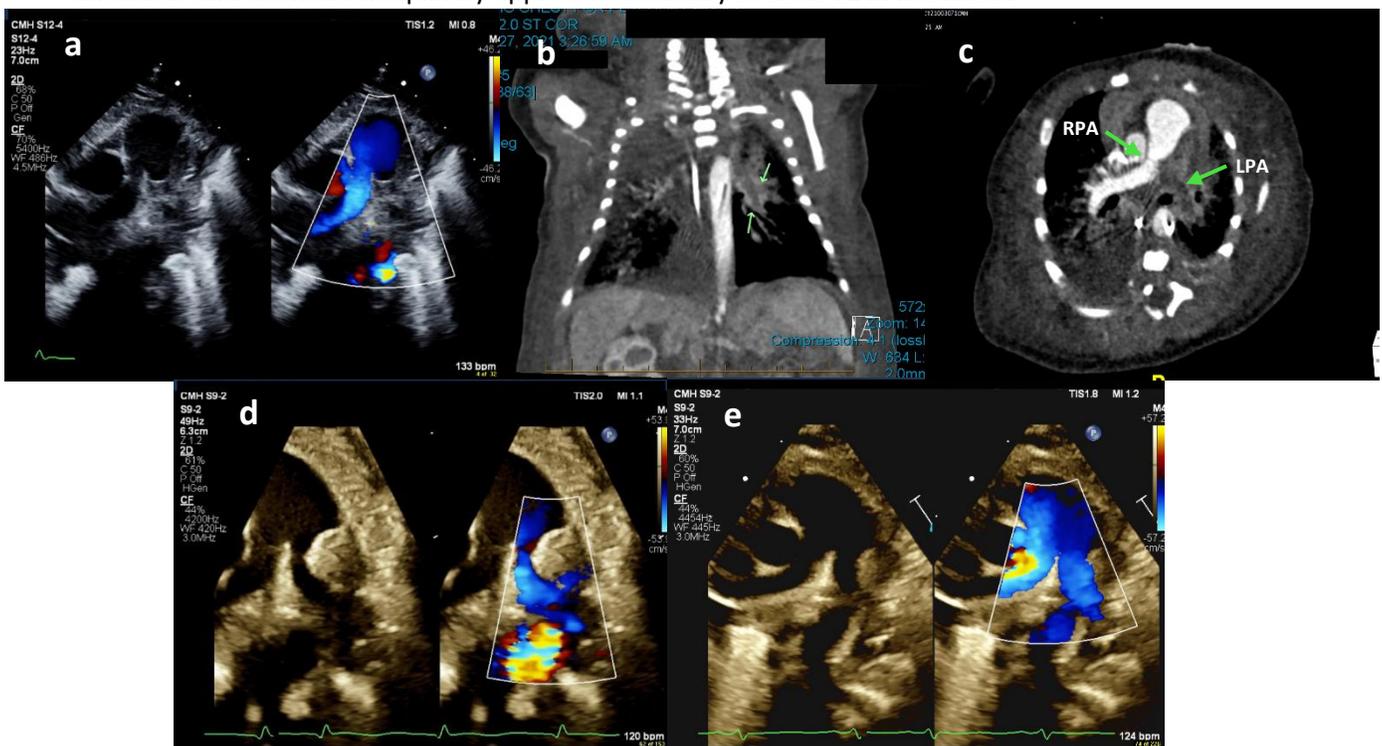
Echocardiographic and CT imaging
